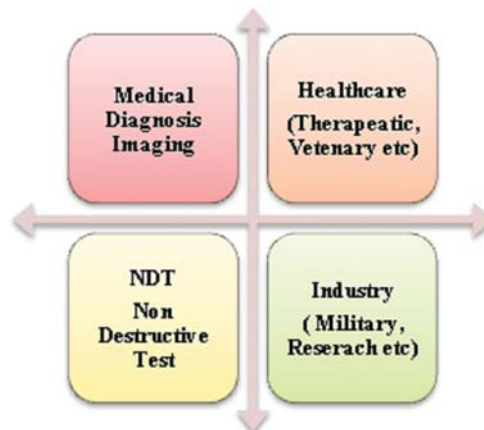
Main Applications of Ultrasound
